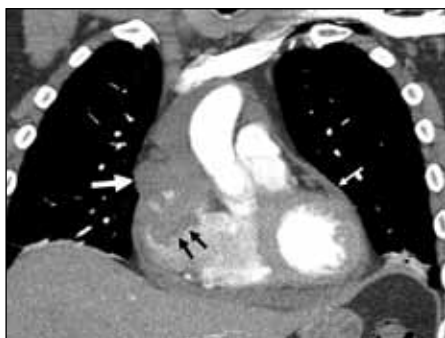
Computed tomographic scan (coronal plane), with intravenous contrast in the arterial phase, showing a mass in the right atrium (two black arrows) with two vascular spaces and extension through the pericardium (single large arrow). There is generalized pericardial thickening and an effusion (single small arrow).
